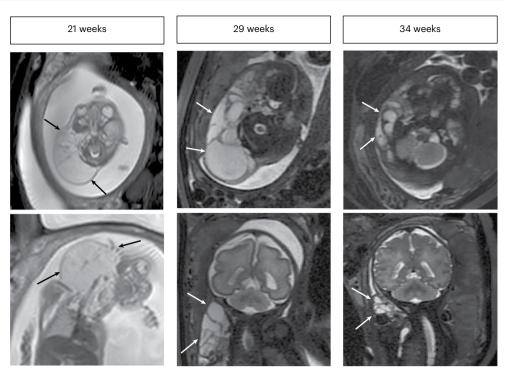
Intrauterine evolution. Fetal MRI of cervical LM (arrows) before sirolimus initiation (21 weeks of pregnancy) and on sirolimus (29 weeks and 34 weeks of pregnancy) in T2-weighted axial (upper) and coronal view (lower).
